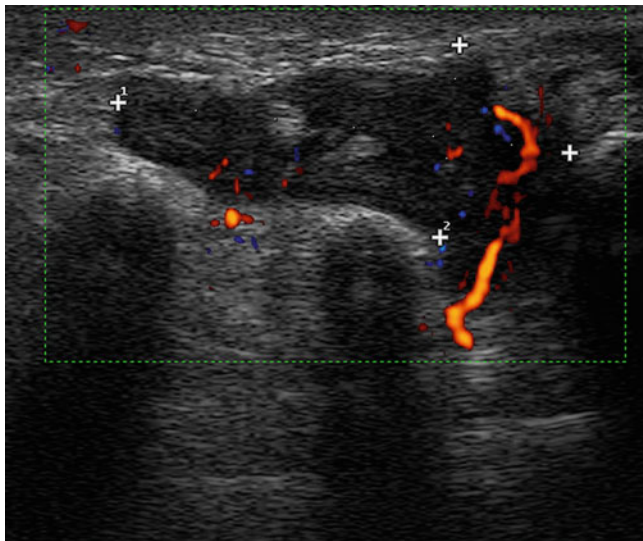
Local melanoma recurrence. Tumor tissue (*calipers*, 29×12 mm) with flow signals at directional power Doppler is seen deep into the foot near the metatarsal bones
